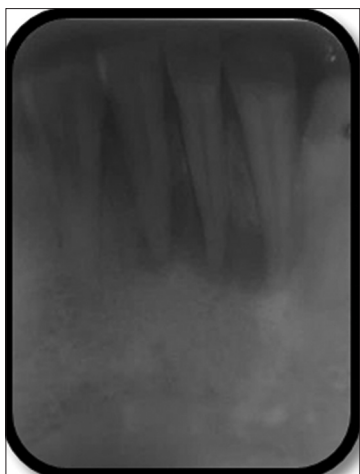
Intraoral periapical radiograph showing large periapical lesions in relation with 31, 32 and 41
